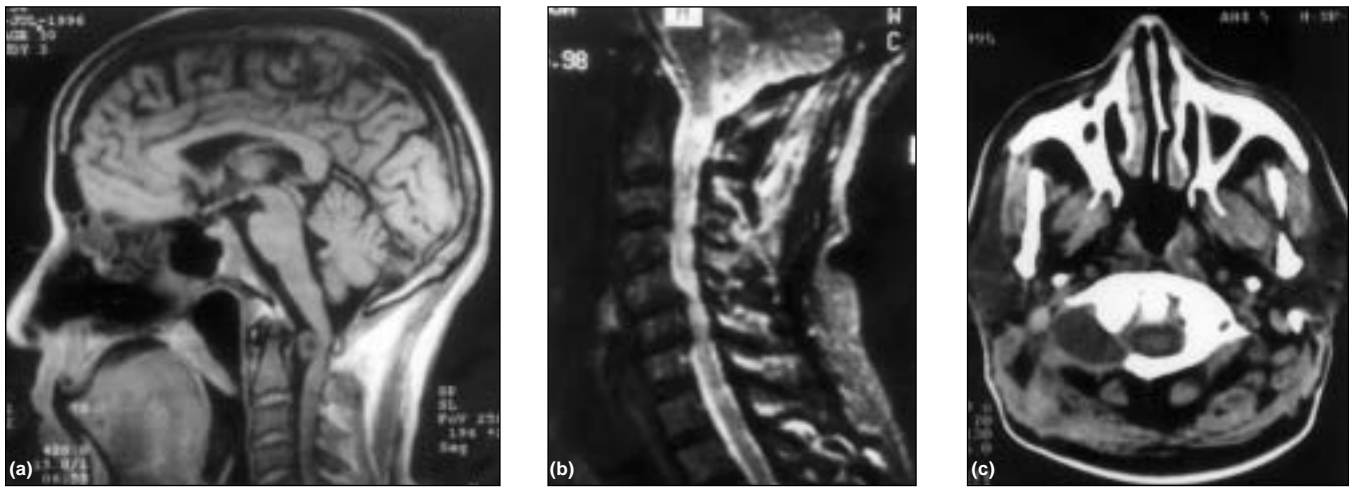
(a) T1-weighted sagittal MR image showing a nerve sheath tumor located anterior to the cord opposite the odontoid causing cervicomedullary compression; (b) T2-weighted MR image showing complete tumor removal using an extreme lateral transcondylar approach. Signal intensity changes are still persisting in the cord opposite the original site of lesion; and, (c) Axial CT image showing the resection of part of the C1 facet and total tumor removal.
